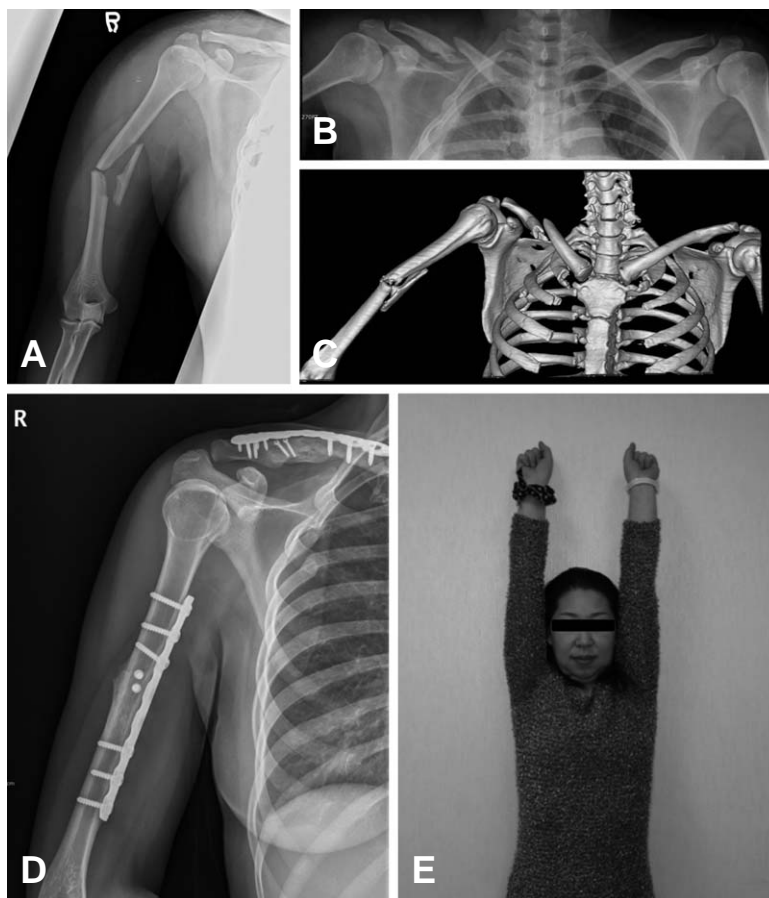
A 31-year-old woman with a case of floating shoulder of the ipsilateral humerus shaft fracture type, sustained in a car accident. (A) Radiograph showing the humerus shaft fracture with butterfly fragments (B) Radiograph showing displaced midshaft clavicle fracture (C) CT scan showing the both fractures (total floating shoulder) (D) Postoperative radiograph at one year, showing plate fixation of both fractures and successful bone union (E) Patient at one year post operation, showing full range of shoulder motion.
